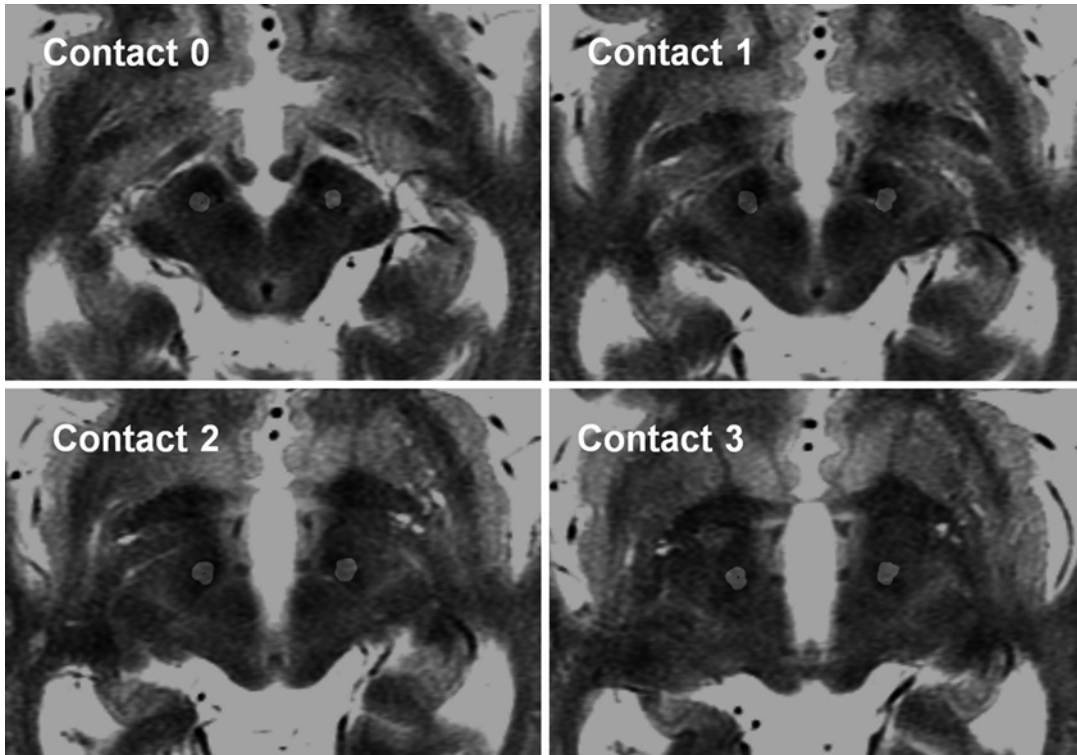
Postoperative CT-preoperative MRI fused image shows artifacts of the electrodes placed within the STN
